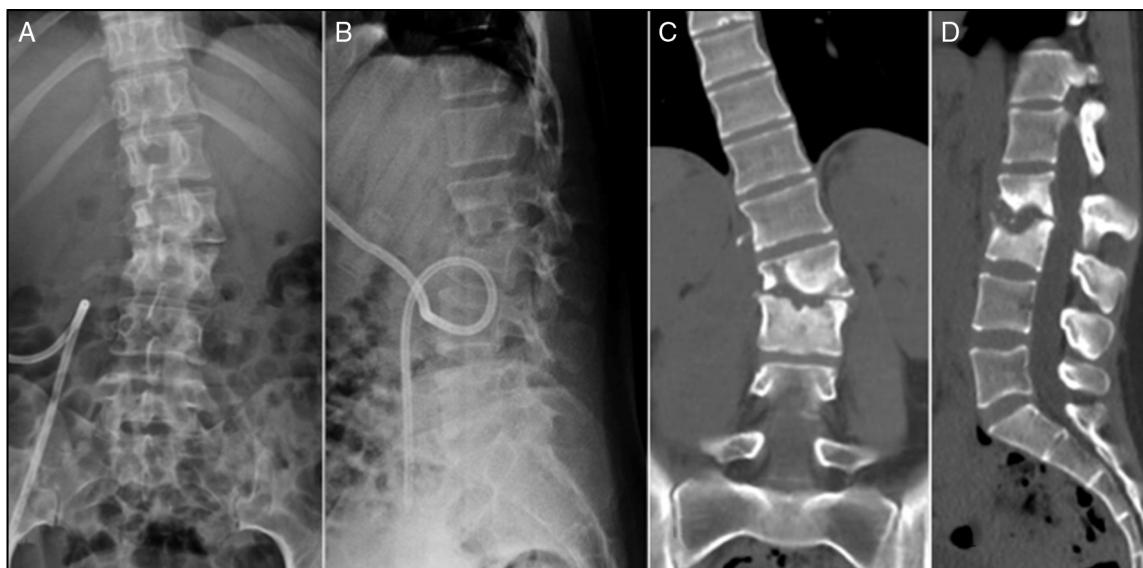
(A) and (B) Anterior and lateral lumbar radiological images with a percutaneous catheter utilized to drain right psoas abscess; (C) and (D) CT-scan showing severe compromise of L2-L3 disk space and vertebral bony destruction.
